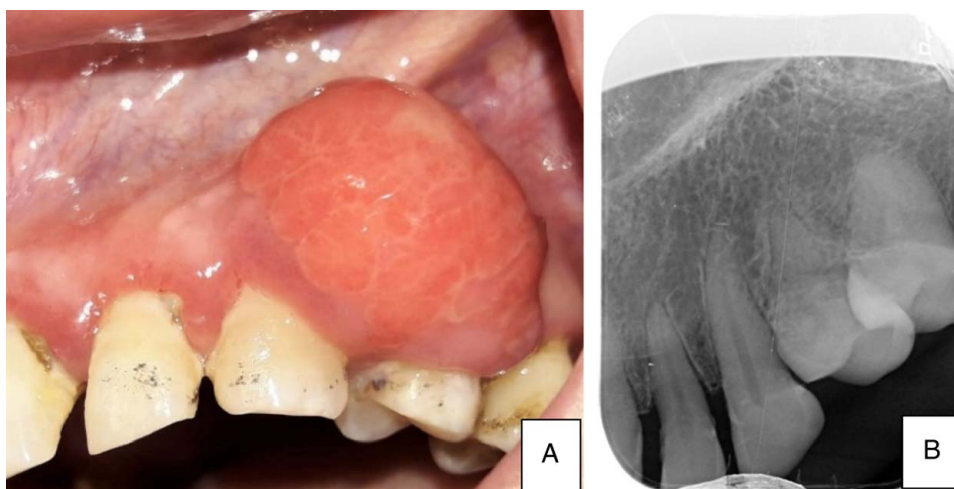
A: Preoperative view showed Gingival growth measuring about 2 cm – 1.5 cm in size. B: Intraoral periapical radiograph showing initial interdental alveolar bone loss between 23 and 24.
